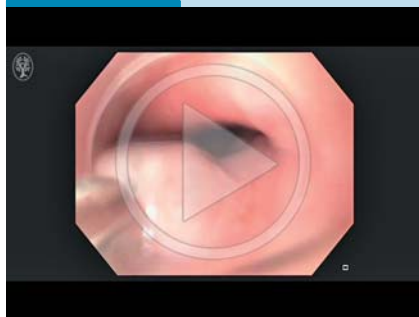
Proximity of an esophageal subepithelial leiomyoma to the aorta in a 71-year-old woman with dysphagia and weight loss, seen on radial endoscopic ultrasound.
